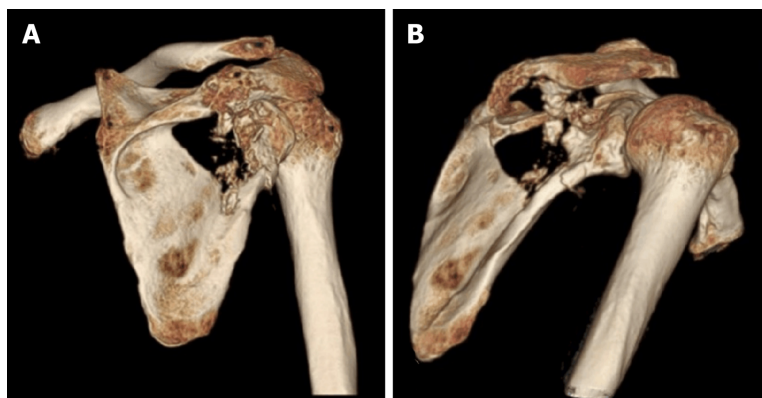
Three-dimensional computed tomography reconstruction. A and B: Osteolytic destructive lesion in the right scapular bone.
